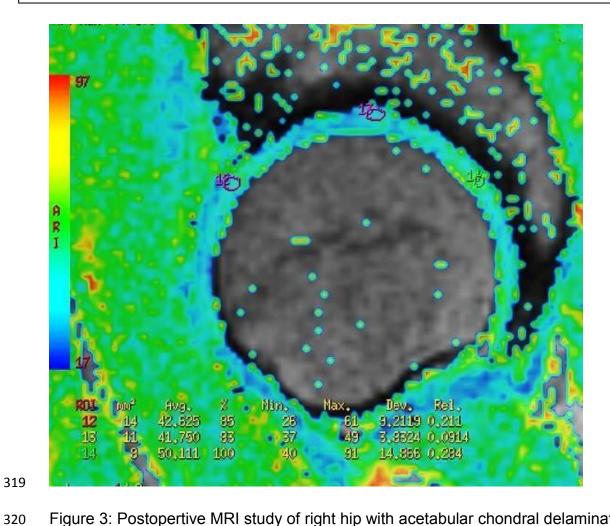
Postopertive MRI study of right hip with acetabular chondral delamination after treatment with chitosan-based scaffold . Sagittal T2 mapping image with 3 ROIs and corresponding T2 values.
